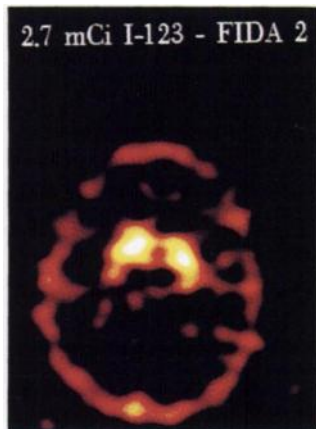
Transaxial image of a healthy human brain at the level of the diencephalon. The images were acquired with only 100 MBq (2.7 mCi) ^{123}I -FIDA-2 on a triple-headed SPECT system equipped with fanbeam collimators. A count rate dependent prefilter was applied before the images were corrected for attenuation.
